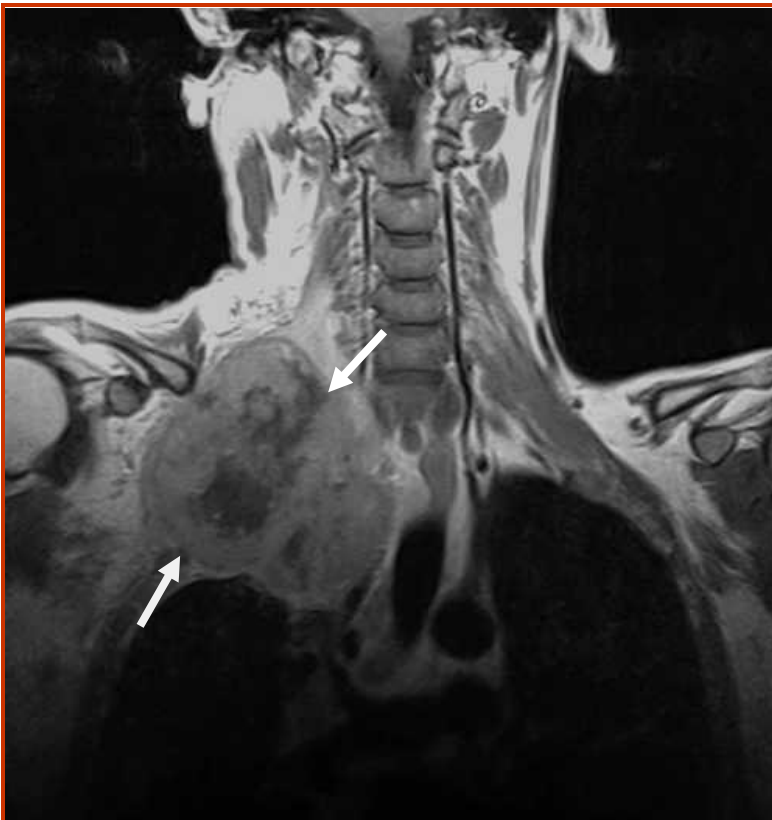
Coronal T2-weighted MRI a thorax. A tumor (cancer) of a top of the right lung, sprouting in soft tissues and a backbone (arrows)
